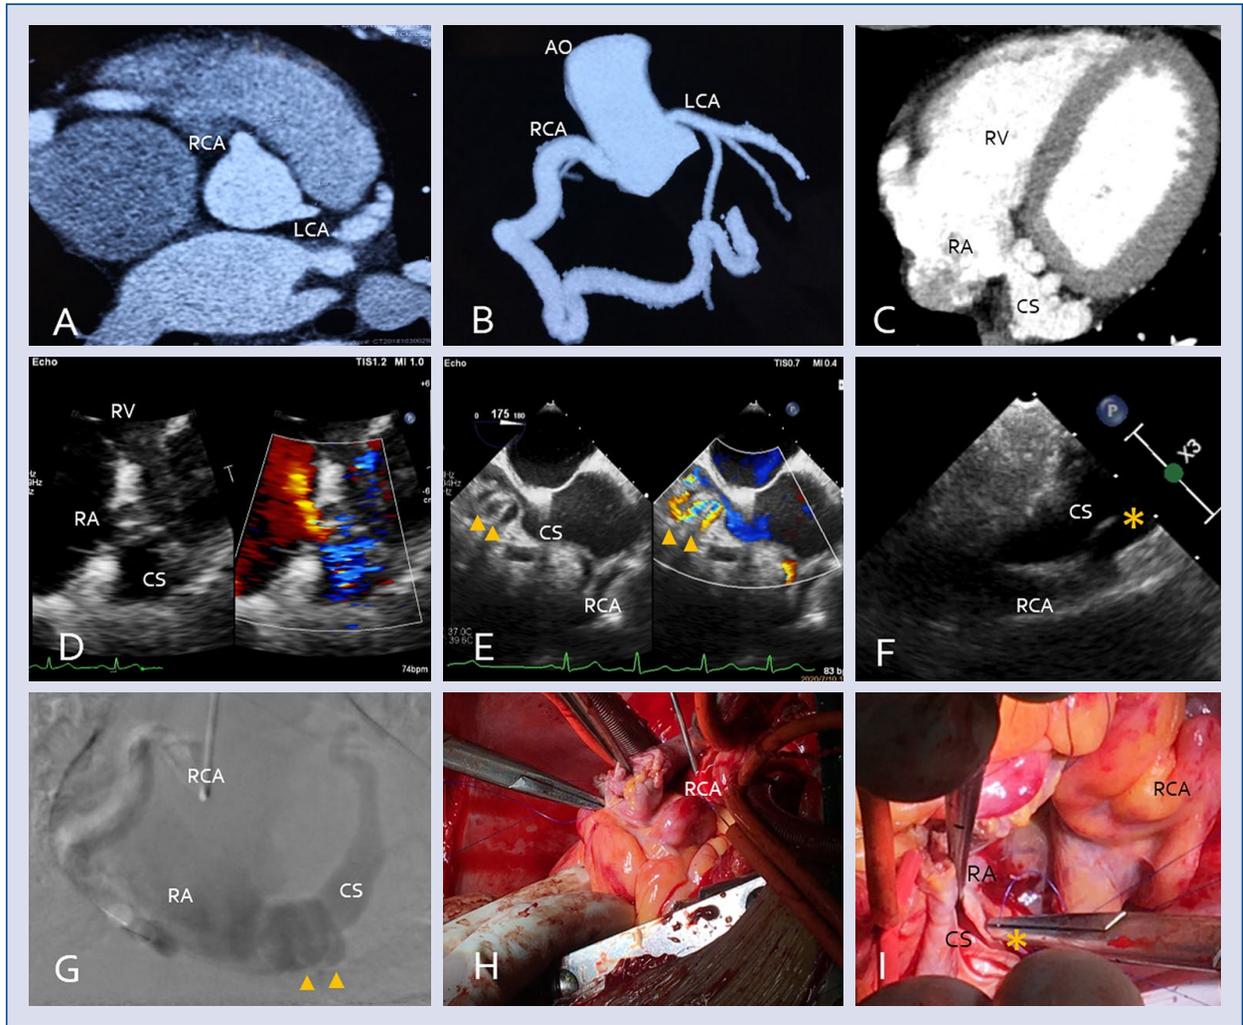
A–C. The coronary artery computed tomography angiography (CTA) showed the origin of a tortuous dilated right coronary artery (RCA), its course and a dilated coronary sinus (CS); D. Transthoracic echocardiography showed a bright flow from the dilated CS; E, F. Transesophageal echocardiography showed a hairpin-like coronary fistula and the defect between the distal RCA and the CS aneurysm (arrow, asterisk); G. The angiography demonstrated the termination of the RCA fistula (arrow); H, I. At surgery, the tortuous dilated RCA can be seen, while the defect was concealed in the CS (asterisk); LCA — left coronary artery; AO — aorta; RA — right atrium; RV — right ventricle.
